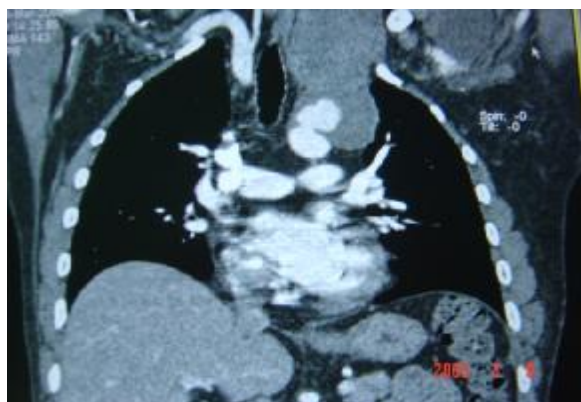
One month CT angiography in Behçet's disease presenting with subclavian artery aneurysm.
